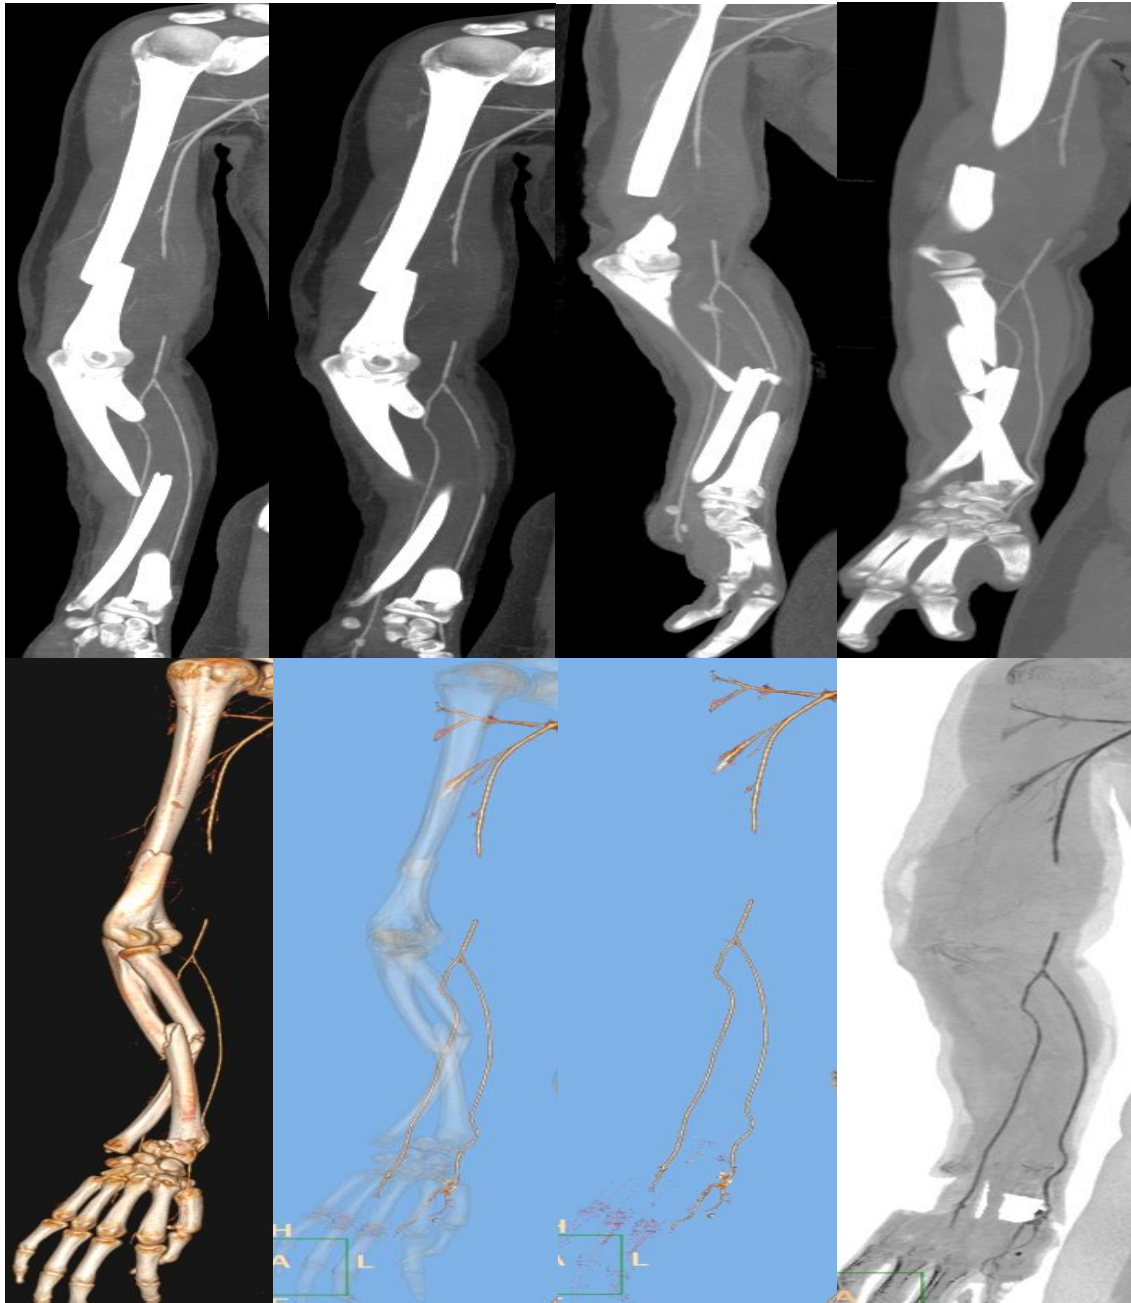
(A-H). CTA multiplanar (MPR)(A-D) and 3D volume rendered (E-G) and positive image (H) reveal fracture lower third of humerus and middle third of both bones of right forearm with displacement of fracture fragments, intramuscular hematoma of arm & forearm and lower third segmental occlusion of brachial artery. Complete segmental transection & rupture was found at surgery.
